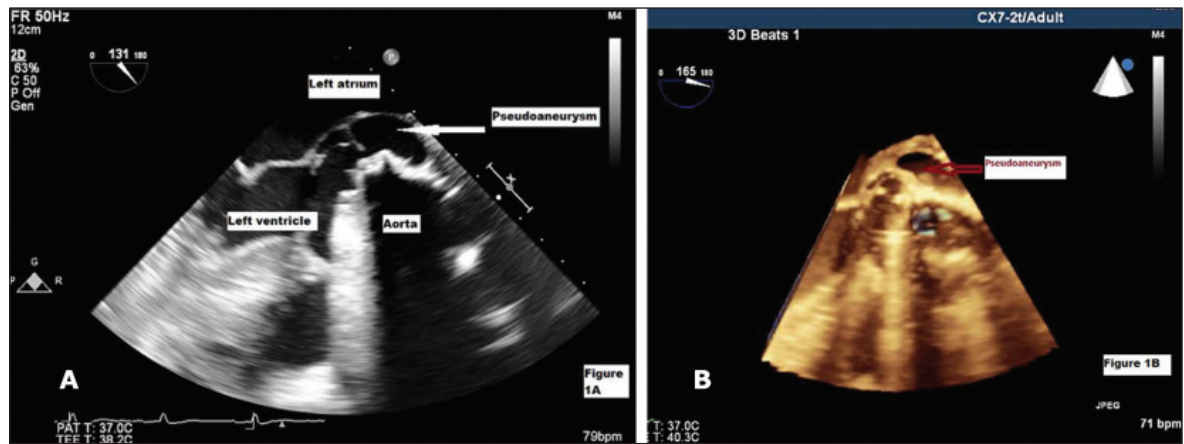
(A) Two-dimensional transesophageal echocardiographic examination showing pseudoaneurysm formation, (B) Three-dimensional transesophageal echocardiographic examination showing pseudoaneurysm formation.
